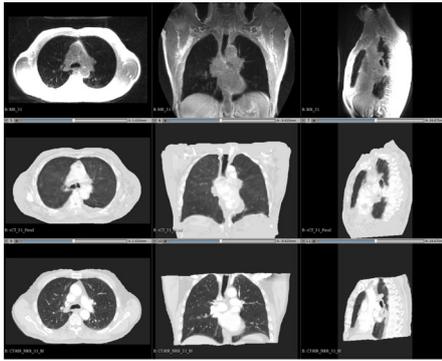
An example of a patient MRI (top), clinical CT scan (bottom) and generated sCT (middle)
